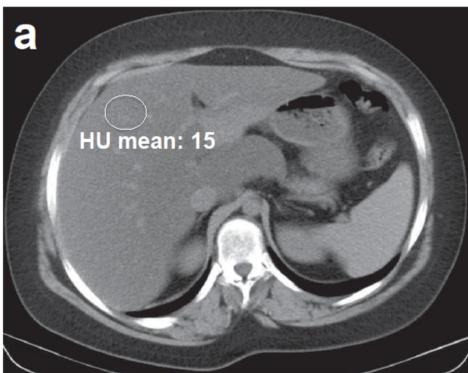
Computed tomography imaging of (a) a patient with severe steatosis hepatitis and (b) with a normal liver. Circles depict the regions of interest in which Hounsfield units (HU) are measured.
